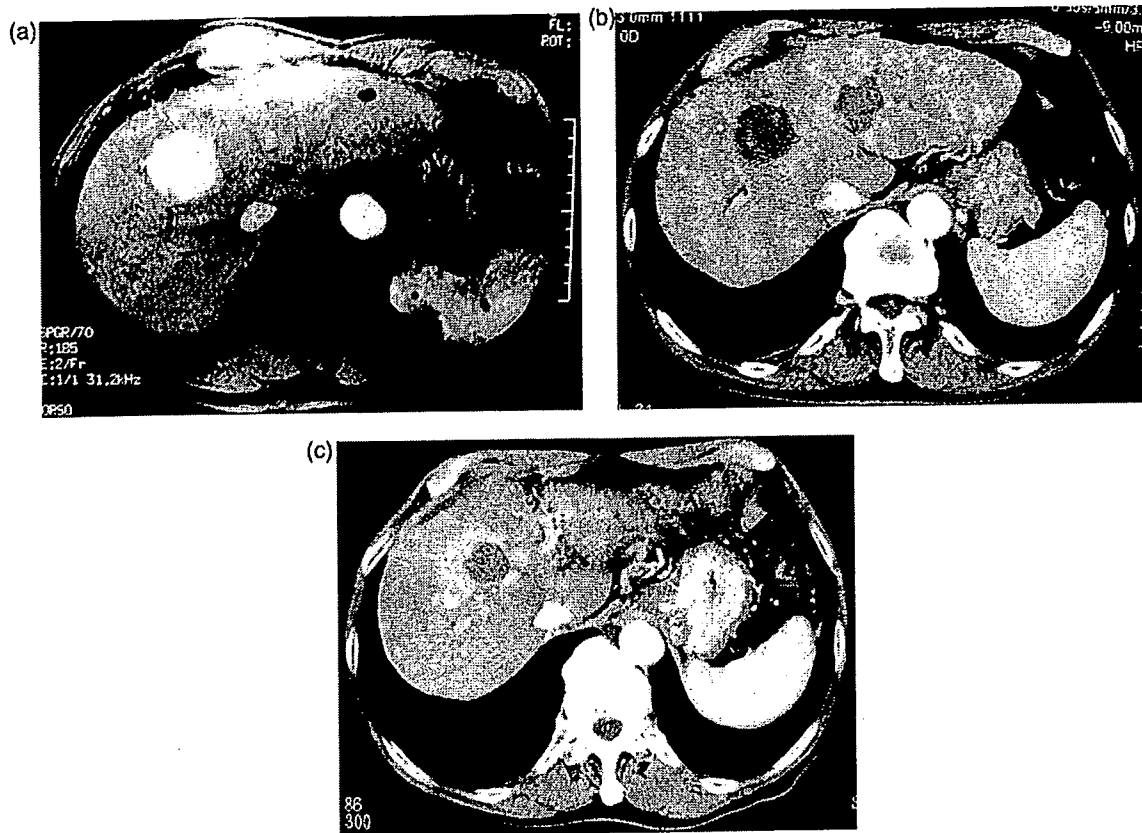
A 71-year-old man with multinodular hepatocellular carcinoma at segment S8-5 and segment S2-3. (a) Pre-RFA, arterial phase dynamic magnetic resonance (MR) imaging reveals two enhanced masses measuring 2.5 cm in segment S8-5 and 1.2 cm in segment S2-3 (arrows). (b) Immediate post-RFA arterial phase dynamic CT imaging reveals periablation hyperemia with complete tumor necrosis. No residual viable tumor could be discerned. Safety margin ablation was sufficient for segment S2-3 mass, although insufficient for segment S8-5 mass because of the hazard of inferior vena cava (IVC) injury. (c) Fifth-month follow-up arterial phase dynamic CT imaging reveals enhanced area along the peripheral margin of segment S8-5 ablation zone, consistent with local recurrence. Note that five risk factors are associated: tumor size >2.3 cm; insufficient safety margin ablation; tumor multiplicity; segmental location S8-5; and age >65 years.
